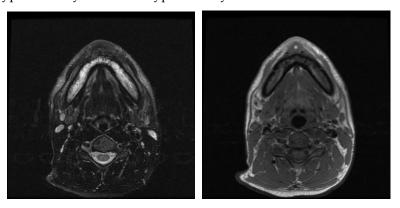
Axial sections of face CT scan showing mandibular bone changes.
